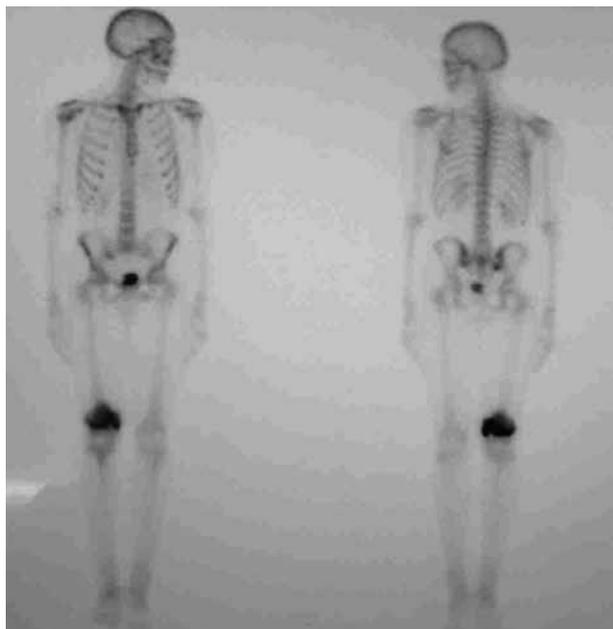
Bone scintigraphy identified the distal femur as an isolated region of increased radioisotope uptake.
